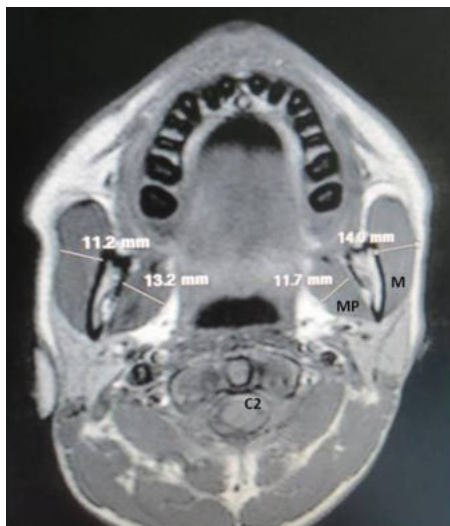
MRI SCAN OF HEAD REGION MEASURING THICKNESS OF
